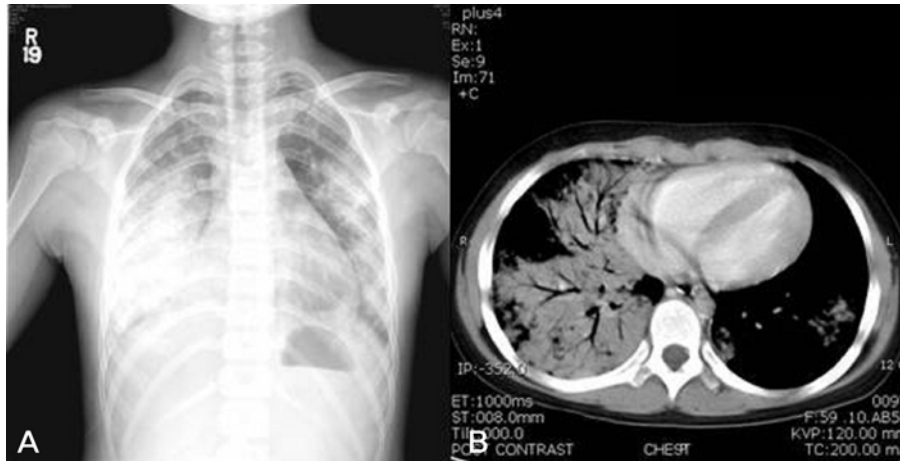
Bilateral diffuse opacities are seen in the postero-anterior chest radiograph (A). Chest CT reveals multiple ground glass opacities and consolidation in both lung fields (B).
